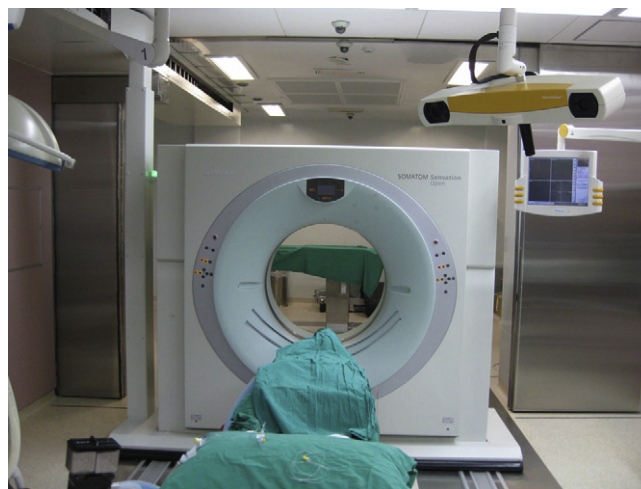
Intraoperative CT scan obtained using an integrated computer navigation system in the operating suite.
